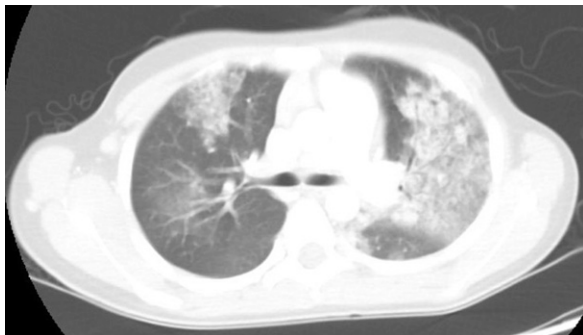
A chest computed tomographic scan shows mixed nodular and ground glass consolidations in both lungs.
